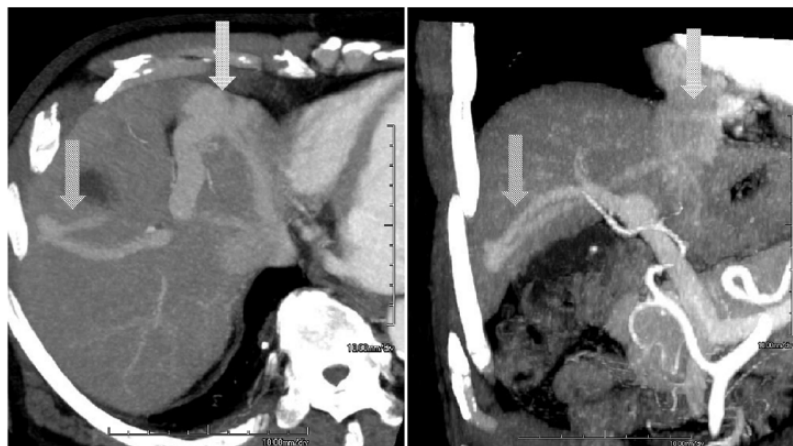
Contrast computed tomography of the abdomen. Striped arrows: a large right portal-middle hepatic venous shunt. Dotted arrows: a left portal-left hepatic venous shunt.
